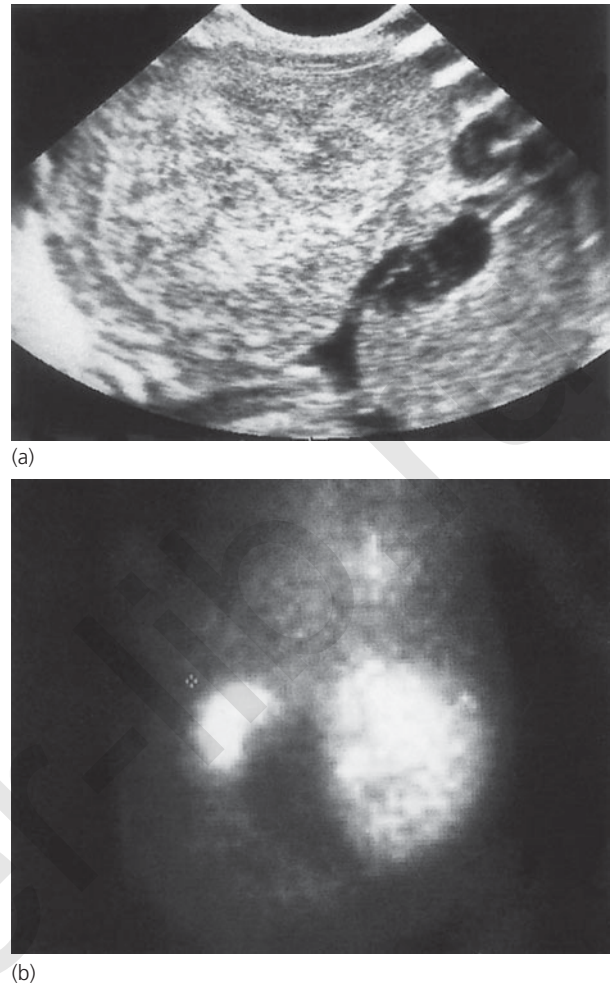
(a) Sonography demonstrates a mixed echogenic mass. (b) ^{99m}Tc-DTPA renal scintigraphy shows function within the mass in the kidney.
